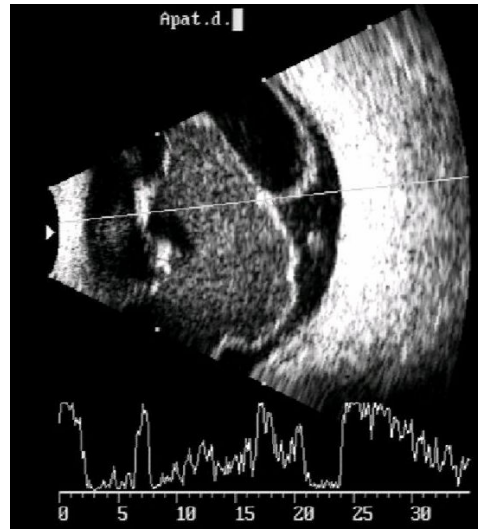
A and B scan ultrasound of intraocular foreign body.
